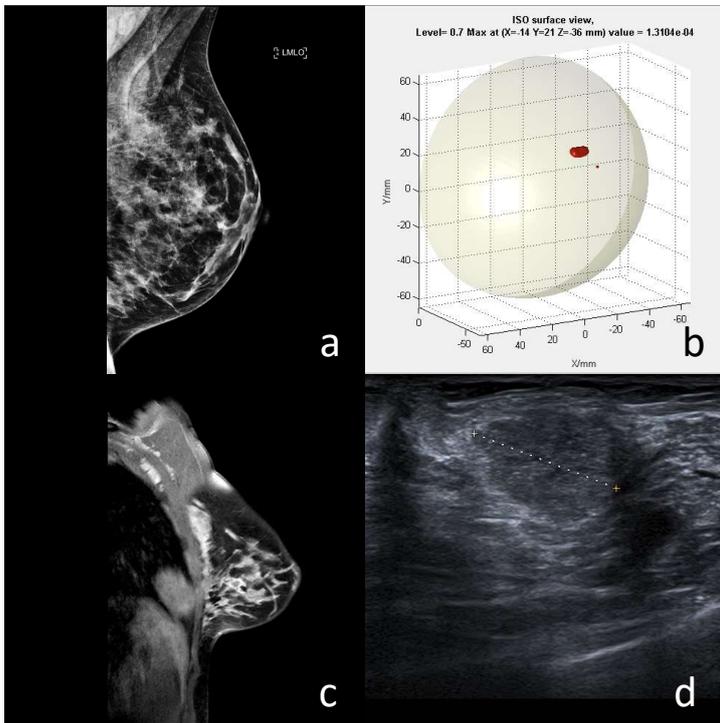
P035 Age 55, BIRAD 'd' Left (a) MMG showing no lesion (b) MARIA showing finding UOQ (c) Gadolinium-enhanced MRI showing 16mm irregular mass UOQ (d) US from image-guided biopsy which confirmed a Grade 2 mucinous carcinoma and DCIS.
